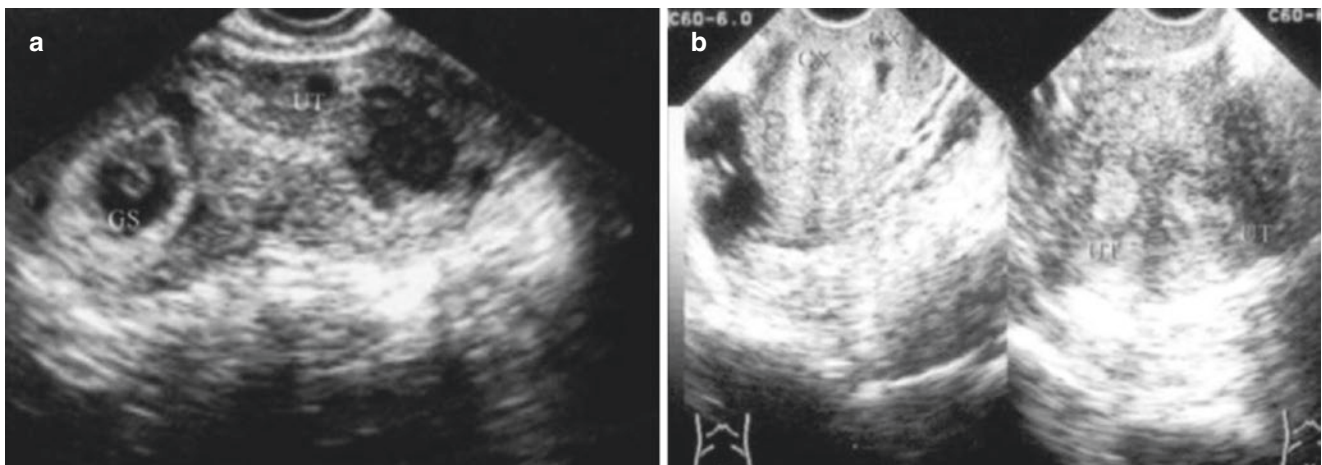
Septate uterus with pregnancy. (a) Septate uterus with early pregnancy in the right cavity. (b) Transvaginal ultrasonography shows only one uterine body and two endometriums from the fundus to the cervix
